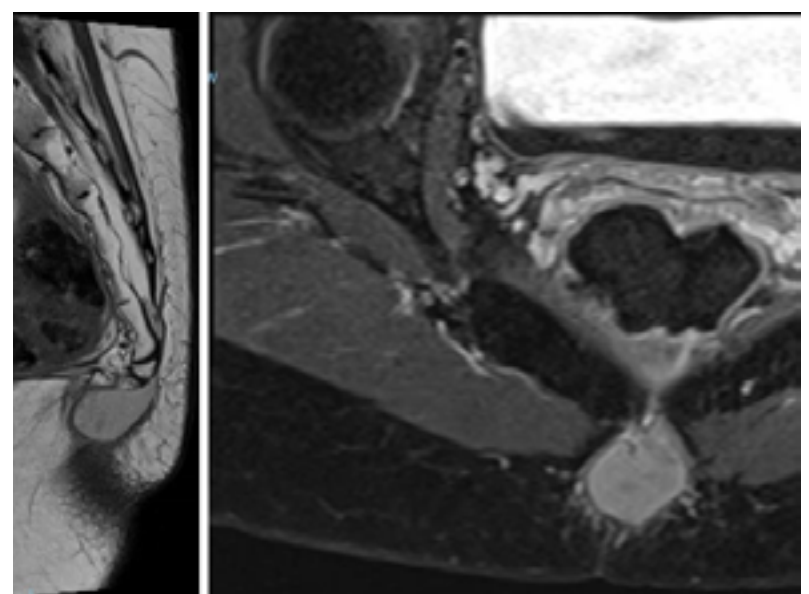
3B: Axial and sagittal views on MRI showing a small tumor of the coccyx, Biopsy revealed a dermoid benign tumor
